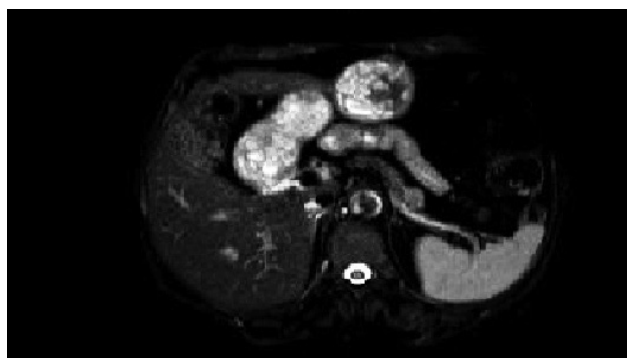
The pancreas MRI shows a hypervascular mass of 15x13 mm in size, hypointense in T1-weighted series, hyperintense in the T2-weighted series in the tail of the pancreas, extending partially out of the contour of the pancreas.
